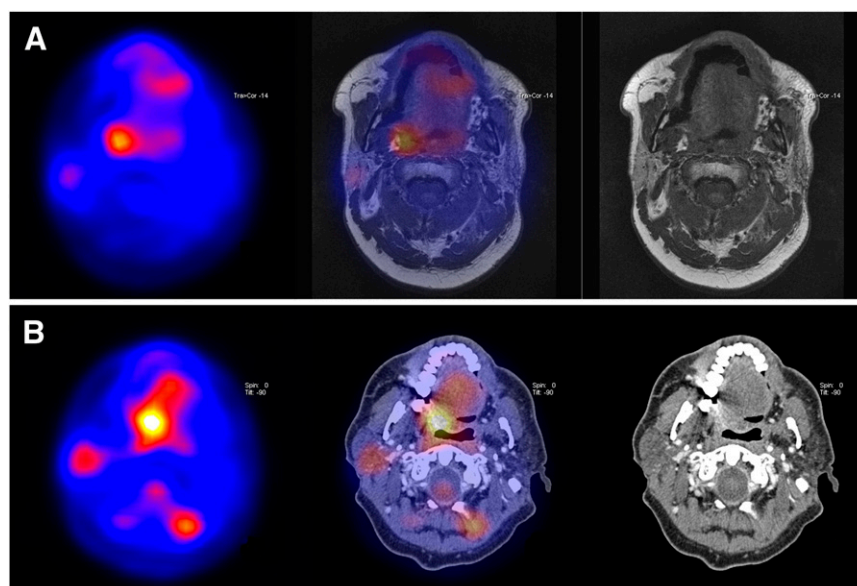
Transaxial ^{18}F -FDG PET images demonstrated false-positive focus present during all 4 scans in first year after treatment, without confirmation by MRI, CT, and follow-up. Here are shown 3-mo (A) and 12-mo (B) post-treatment images.
